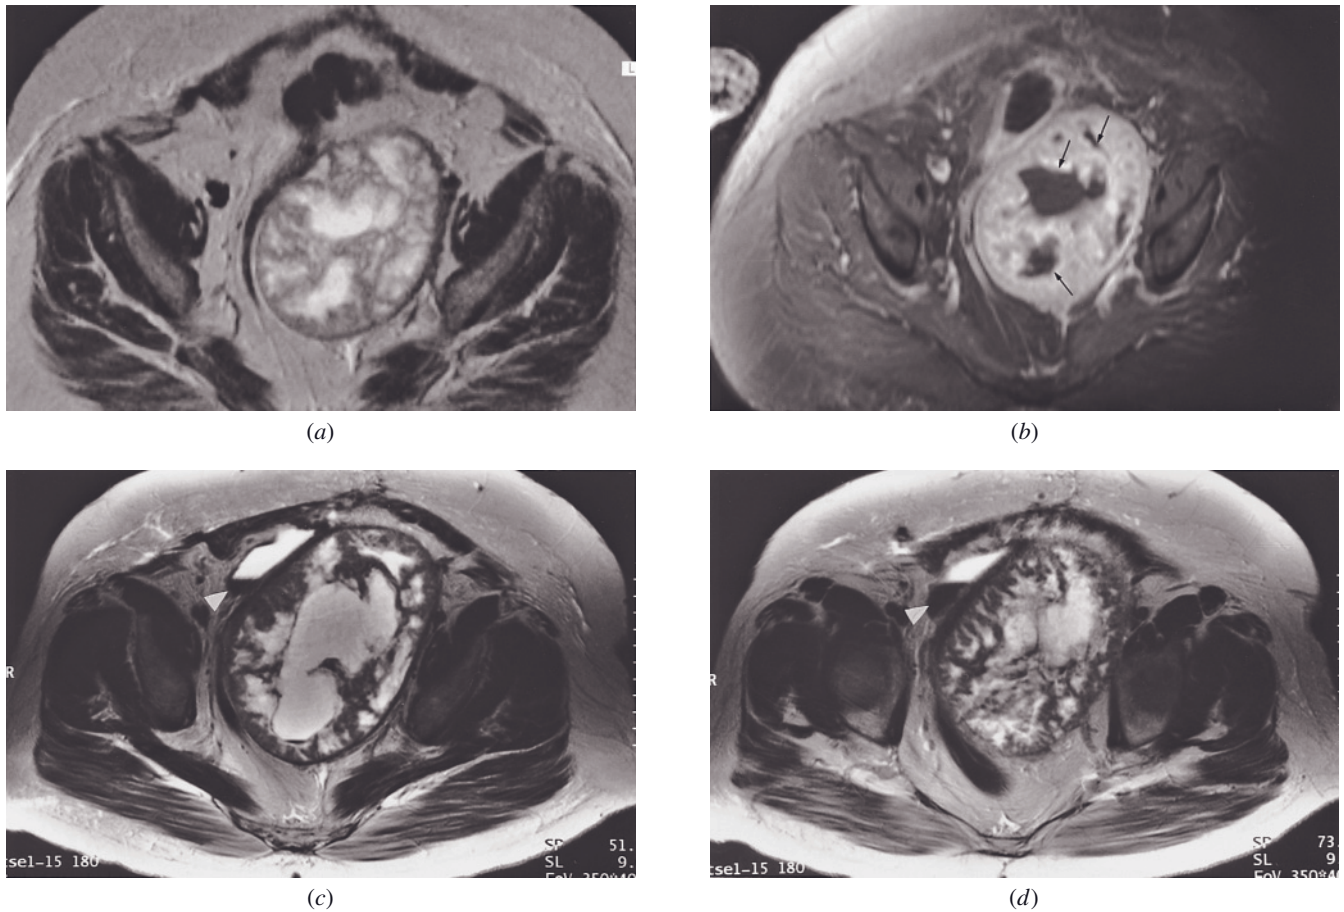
Granulosa cell tumor. Transverse T2-weighted ETSE (*a*) and gadolinium-enhanced T1-weighted fat-suppressed gradient-echo (*b*) images in a woman with a granulosa cell ovarian tumor. The tumor is heterogeneous on the T2-weighted image, and after contrast the solid elements enhance. Necrotic foci interspersed in an otherwise solid mass are a common feature of granulosa-cell tumors (arrows, *b*). Transverse 512-resolution T2-weighted ETSE (*c*, *d*) images 9 months later show interval growth of tumor and increasing necrosis. Note that the bladder is displaced anterolaterally by the mass. Low signal intensity in the dependent portion of the bladder reflects excreted concentrated gadolinium (arrowheads, *c*, *d*).
